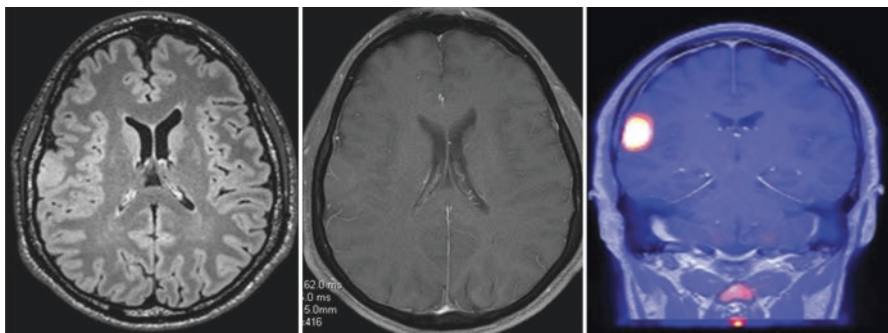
FET-PET/MRI in tumor diagnosis, delineation and grading diagnosis in a 50 y-old patient. MRI: right to left the images show a ill defined, non-enhancing tumor in the right temporal hemisphere. FET PET fused with coronal MRI identifies a focus of uptake at the same level: SUVmax 7.6. Guided biopsy: Pathology: Anaplastic oligoastrocytoma WHO III
